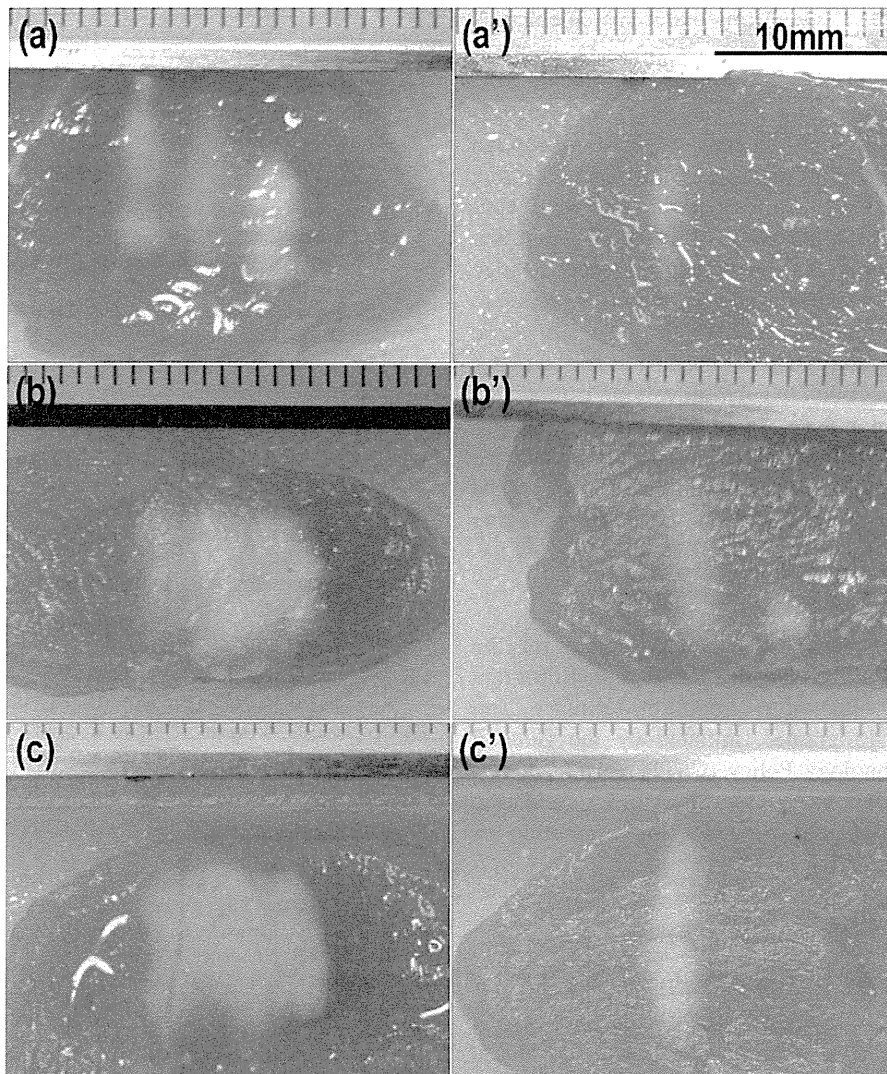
Chicken breast tissue coagulated using the ultrasound sequence.
